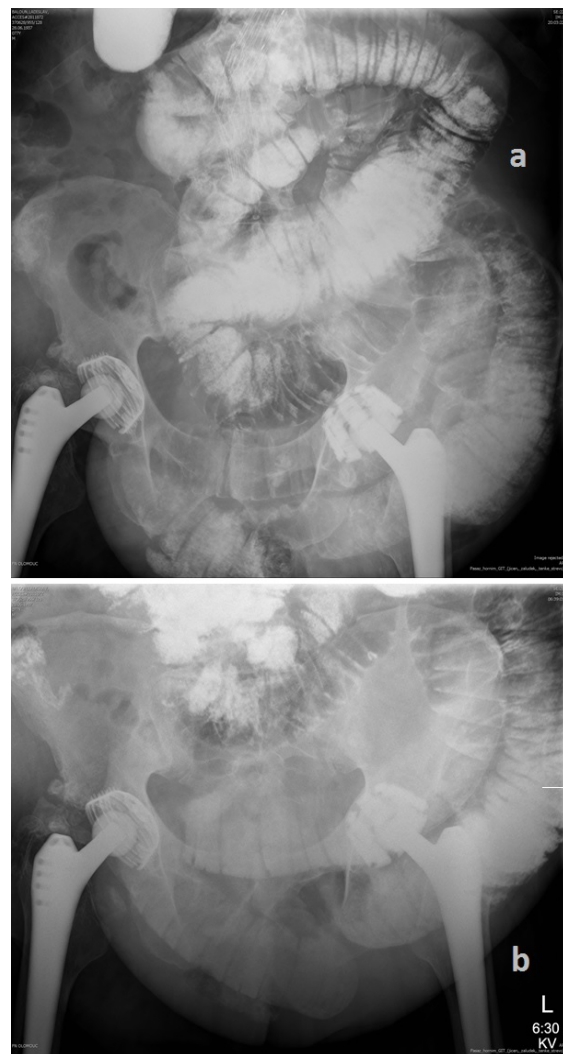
(a,b): X-ray series.
